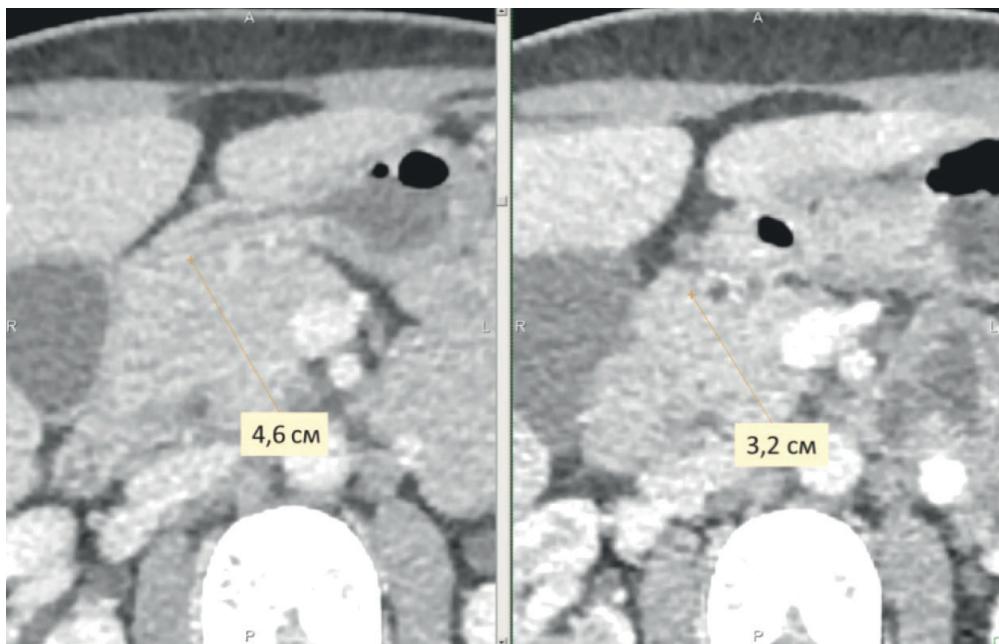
Dynamics of the size of the head of the pancreas according to CT scan data in October 2023 (compared to March 2023)
